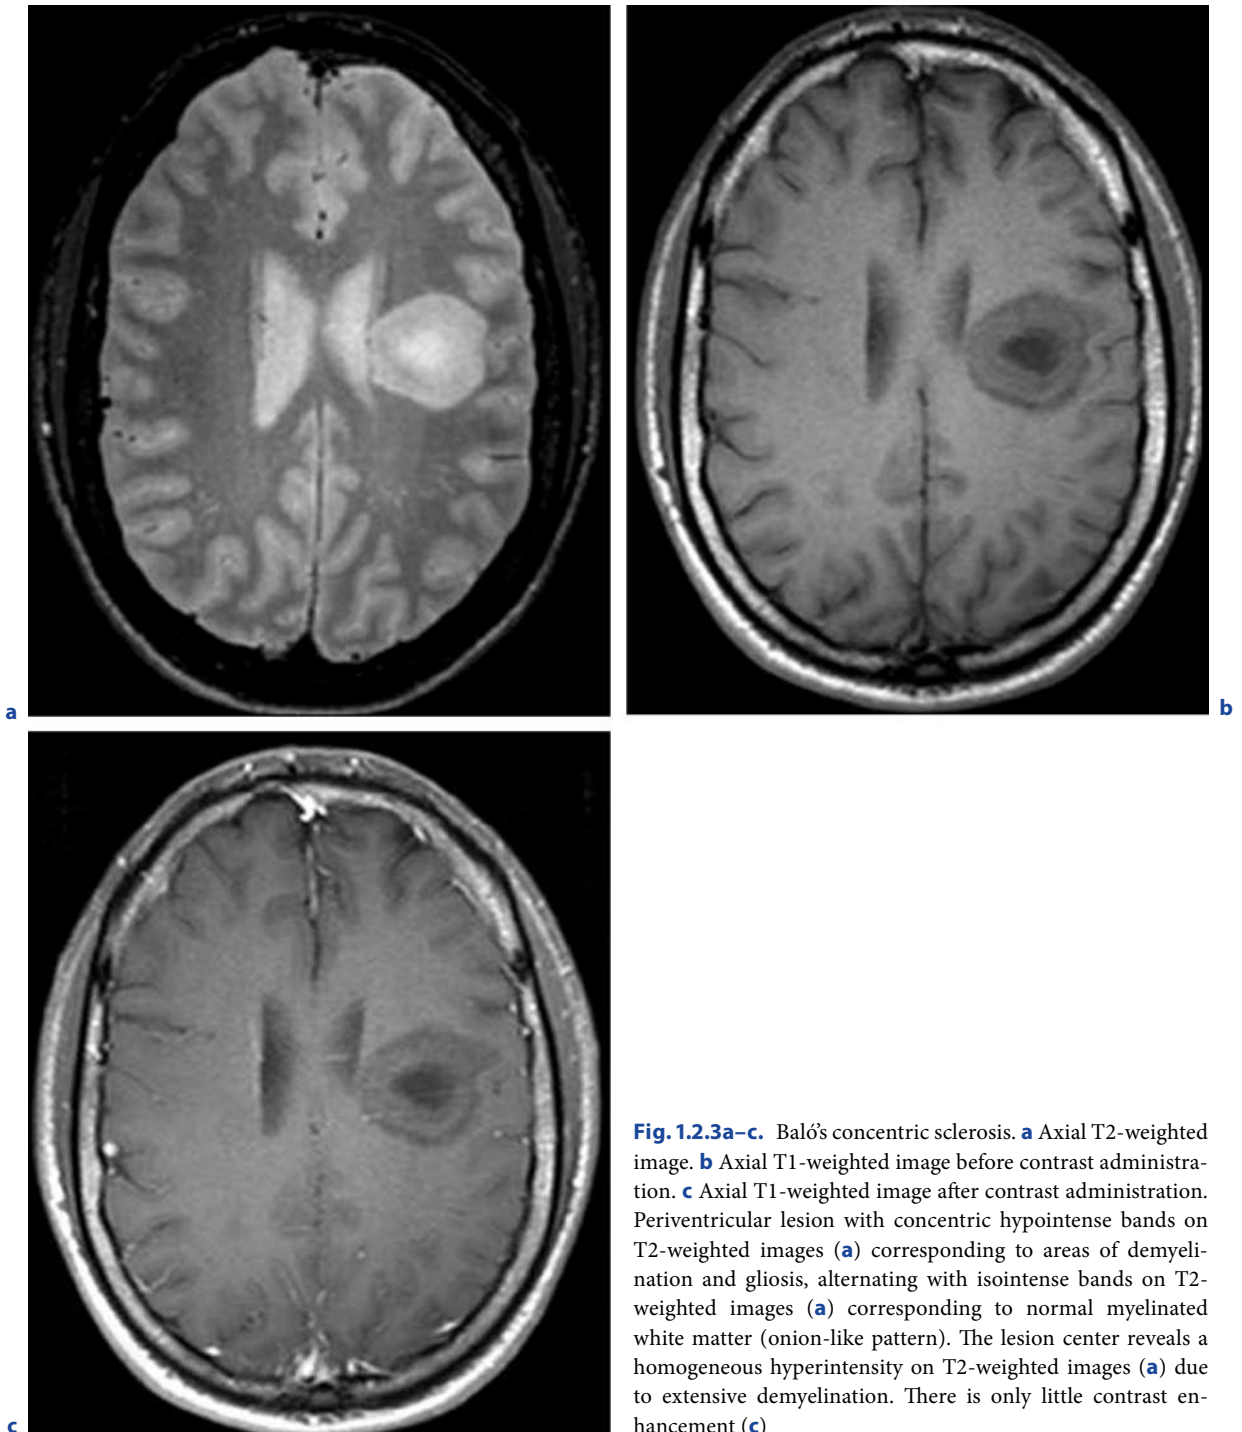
Baló's concentric sclerosis. a Axial T2-weighted image. b Axial T1-weighted image before contrast administration. c Axial T1-weighted image after contrast administration. Periventricular lesion with concentric hypointense bands on T2-weighted images (a) corresponding to areas of demyelination and gliosis, alternating with isointense bands on T2-weighted images (a) corresponding to normal myelinated white matter (onion-like pattern). The lesion center reveals a homogeneous hyperintensity on T2-weighted images (a) due to extensive demyelination. There is only little contrast enhancement (c)
